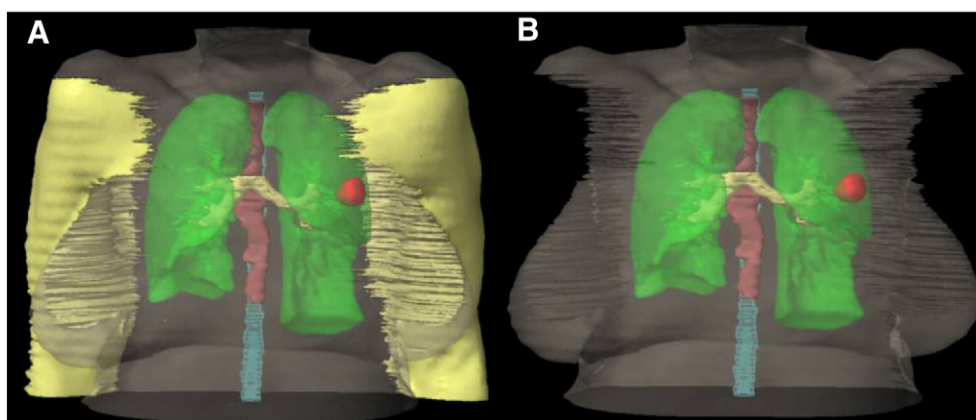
Digital arm subtraction. Three-dimensional rendering of a computed tomography structure set of a patient with a left lung tumor in the arms down position (A) and with the arms digitally subtracted (B). The arms are contoured yellow, the lungs green, the spinal cord cyan, the esophagus brown, the bronchial tree yellow, and the planning target volume red.
